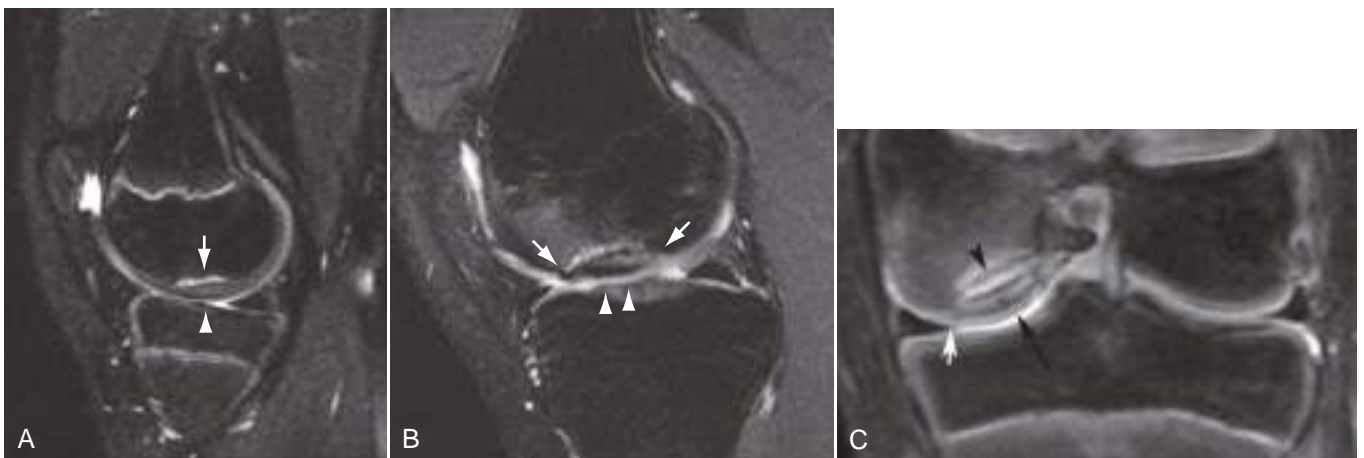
Osteochondritis dissecans (OCD) progression over time to loose in situ fragment. (A) Sagittal fat-suppressed T2-weighted MR image shows incomplete transverse fracture in subchondral trabecular bone (arrow) with completely intact overlying articular cartilage (arrowhead). (B) Same patient 7 years later, now a young adult. The OCD lesion has progressed to a loose in situ fragment. Edema completely separates the host bone from the OCD fragment, including through articular cartilage at the lesion margins (arrows). Also note edema in degenerating fragment cartilage (arrowheads). (C) Coronal fat-suppressed proton-density MR image of the left knee in a different child shows medial femoral condyle OCD fragment (long arrow) and high T2 signal between the fragment and the host femur (arrowhead), indicating that the fragment is loose, despite intact medial articular cartilage (short white arrow).
